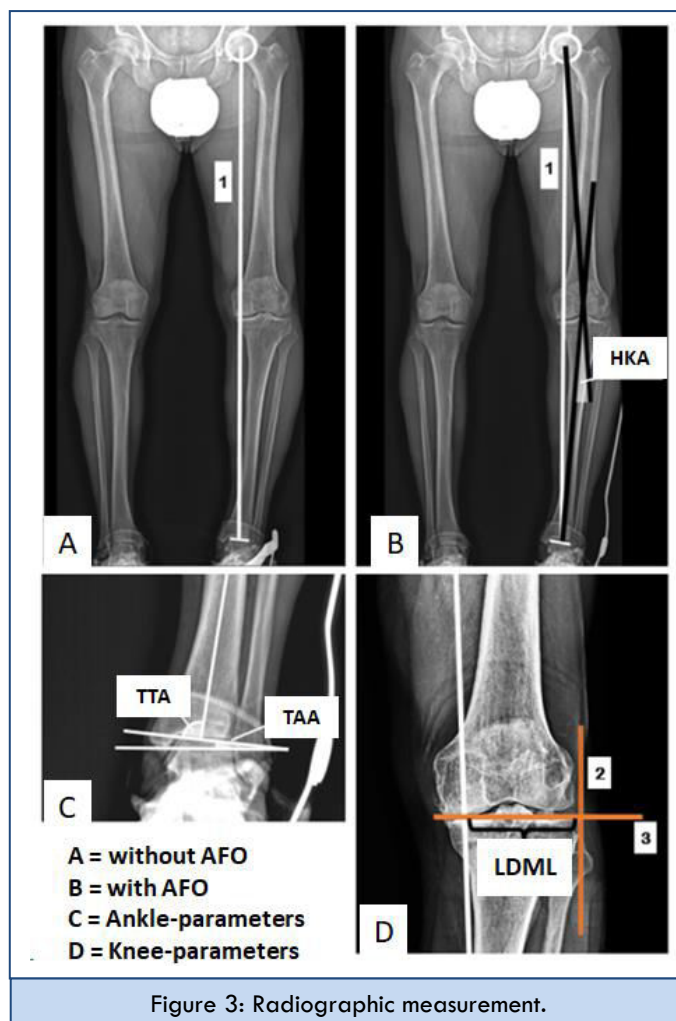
Radiographic measurement.
